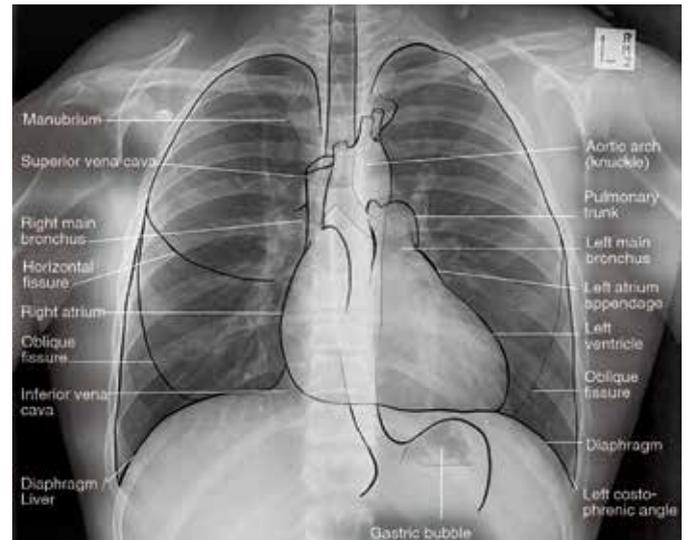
A normal frontal chest radiograph, with the main structures sketched and annotated. Note that, of the fissures, only the horizontal fissure and the lower end of the oblique fissure on the right might be seen on a normal CXR
